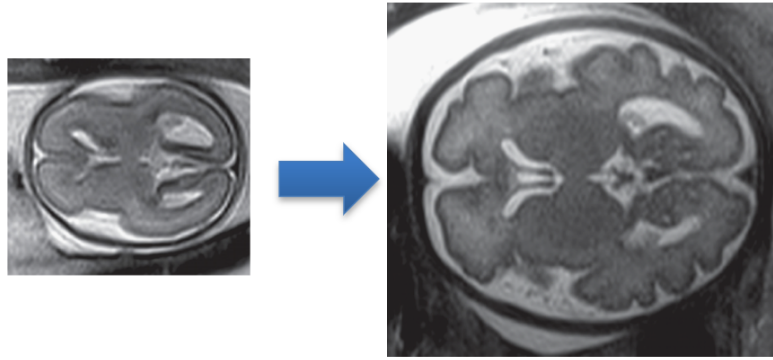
MRI of a fetal brain showing the evolution from 20 to 40 weeks' gestation. The external darker layer corresponds to grey matter.
